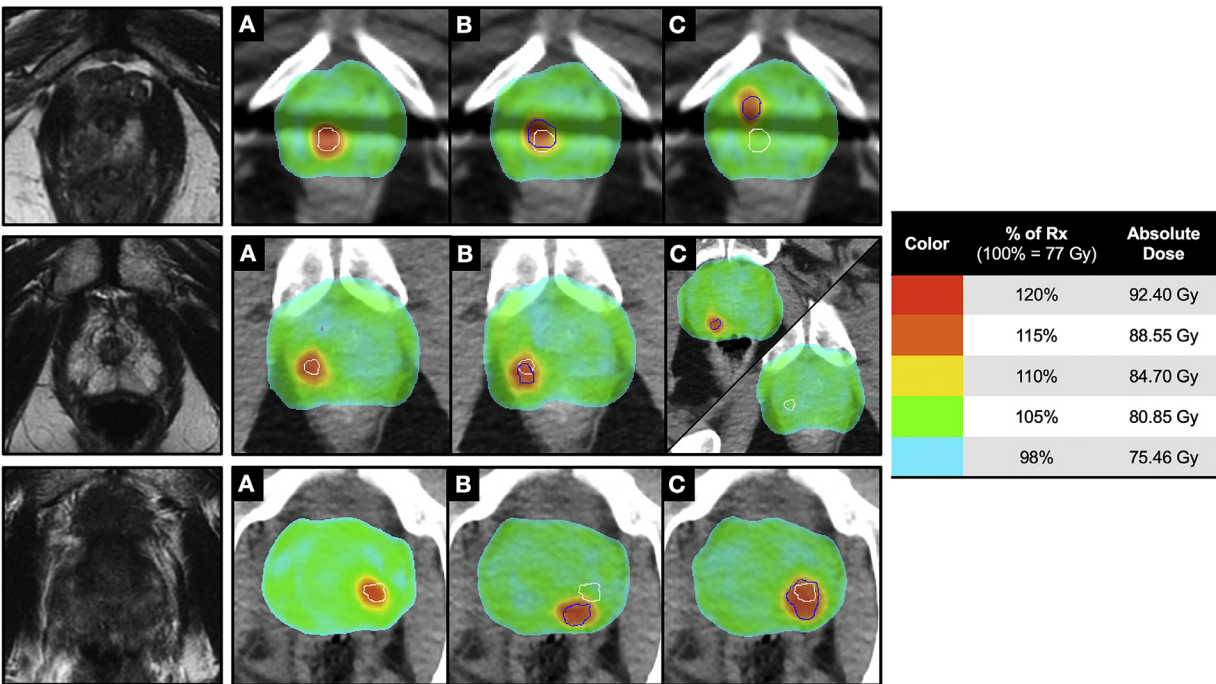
Example contours with dose overlays and corresponding T₂-weighted MRI for 3 patient cases: (A) Expert, (B) and (C) Participants. Expert contours are shown in white, and participant contours are shown in blue. The greater the accuracy of the participant contour, the higher the dose delivered to the true tumor. When the participant drew the contour larger than and including the expert contour (such as in patient 8[C]), this led to a higher dose to the true tumor than that seen in the expert plan.
